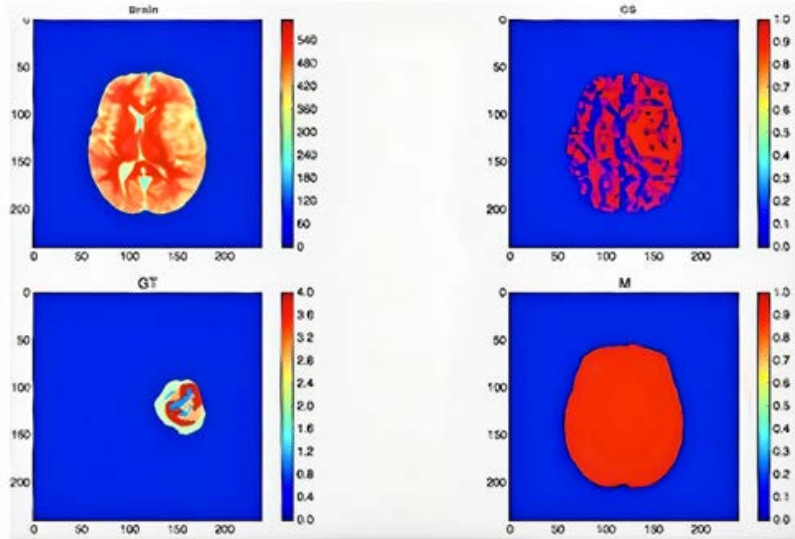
T1-weighted MRI confidence surface
